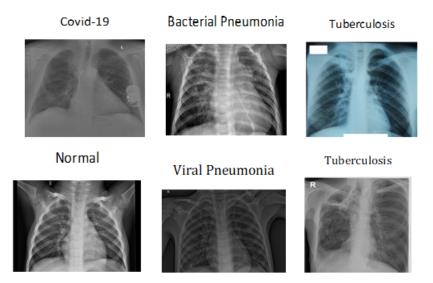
Sample Chest X-ray Images of used datasets before Augmentation
